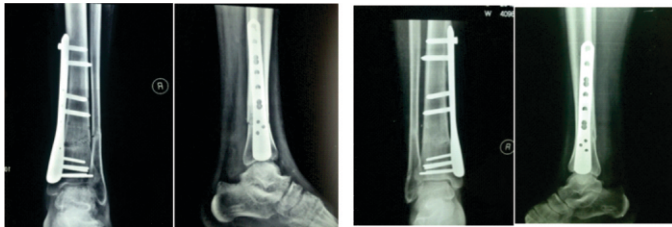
X-Rays showing fracture distal tibia fixed with MIPPO technique.
